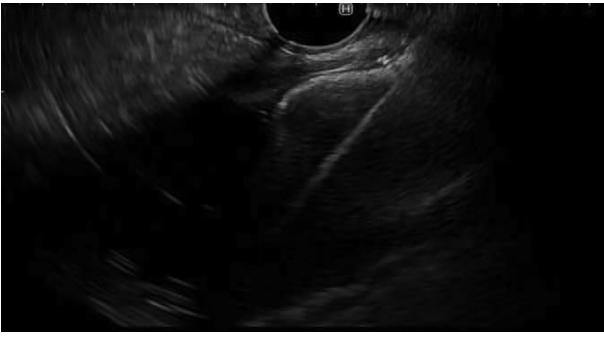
Release of the distal flange of the lumen-apposing metal stent under endoscopic ultrasound guidance.
